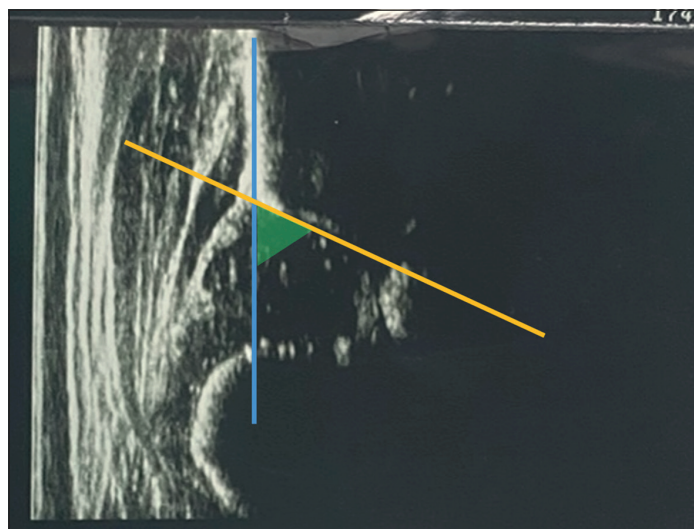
Measurement of the α angle on hip ultrasound according to the Graf method. The image shows a static coronal view of the hip in the neutral position. The baseline (blue) is drawn along the osseous margin of the ilium. The acetabular roof line (yellow) extends from the lateral edge of the acetabulum to the transition point with the ilium. The α angle (green area) is formed between both lines and represents the inclination of the osseous acetabular roof.
